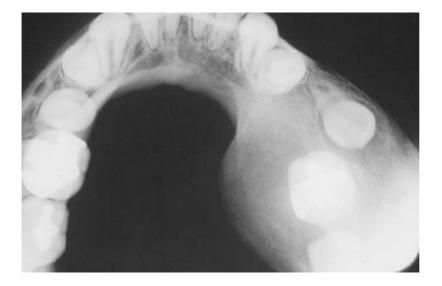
Fibrous Dysplasia. Occlusal radiograph showing localized expansion of the mandible and the "ground-glass" radiographic appearance. The margins of the lesion are not well defined and blend into the adjacent bone (Waldron CA and Giansanti JS,1973).
